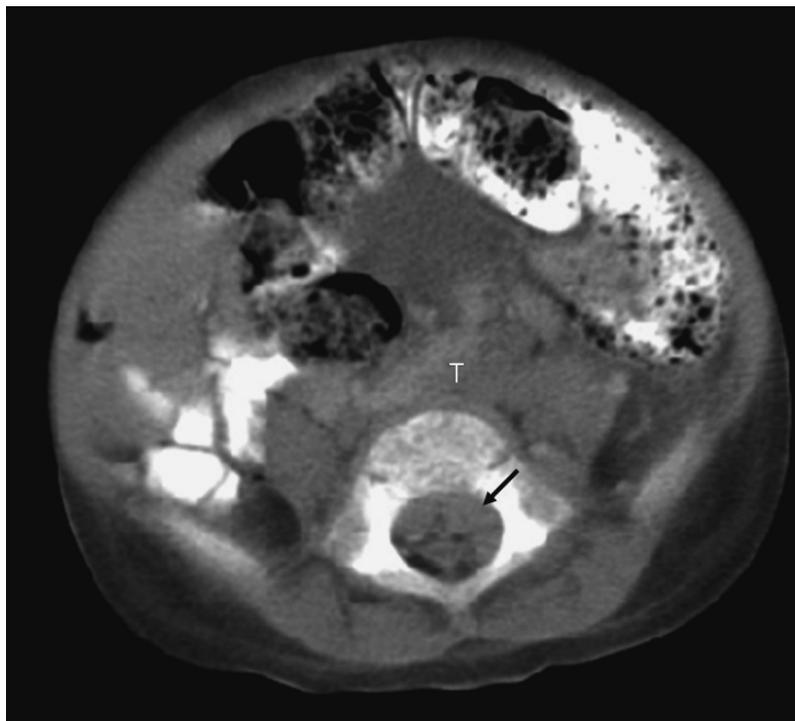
An abdominal CT scan of a 3-year-old child with disseminated neuroblastoma. The retroperitoneal tumor can be seen (T), as can extension of the tumor within the spinal canal (black arrow). This child presented with lower extremity neurologic deficit.
